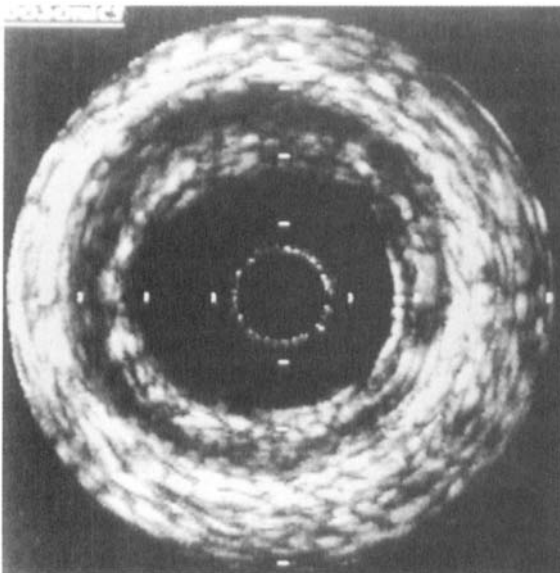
Intracoronary ultrasound image from the left anterior descending artery of a transplant recipient in our series. The severity of disease in this patient was graded as class IV ($>0.5\text{mm}$, $>180^\circ$) according to the Stanford classification system.⁶
